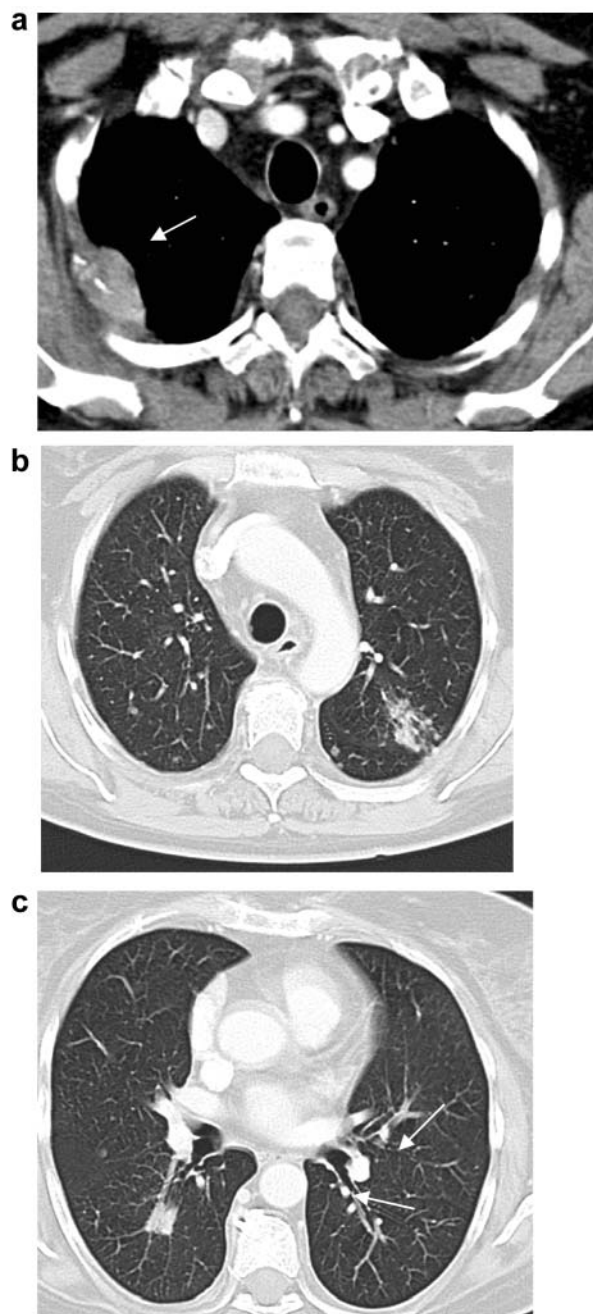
CT examination after contrast medium infusion revealed: (a) the presence of metastases on the rib (b) and bilaterally in the lung (c) (arrows).
